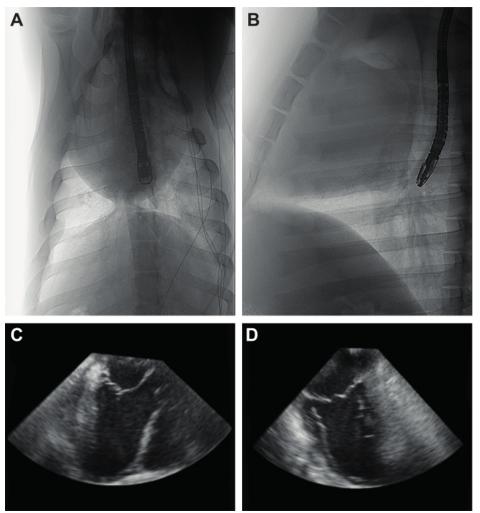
Positioning and Acquisition of 3D TEE Images. Anteroposterior (A) and mediolateral (B) X-ray images of the 3D-TEE probe positioning in the esophagus. Image acquisition follows upon correct visualization of the left atrium, left ventricle and aorta (C) and a perpendicular image of both left atrium and left ventricle (D). 3D-TEE: three-dimensional transesophageal echocardiography. Please click here to view a larger version of this figure.
